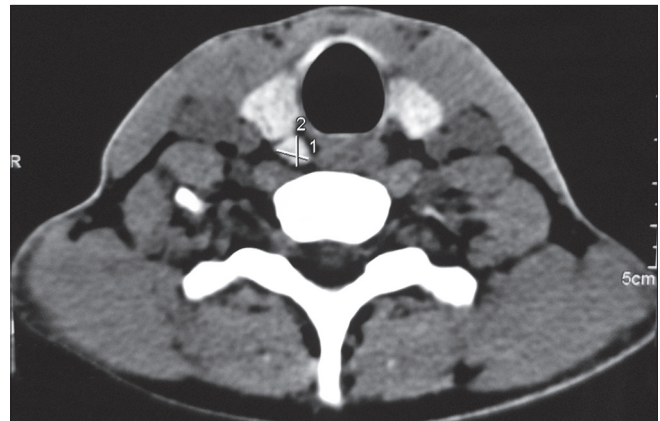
Computed tomography neck showing enlarged the right parathyroid gland (0.77 cm × 0.71 cm × 1.4 cm)
